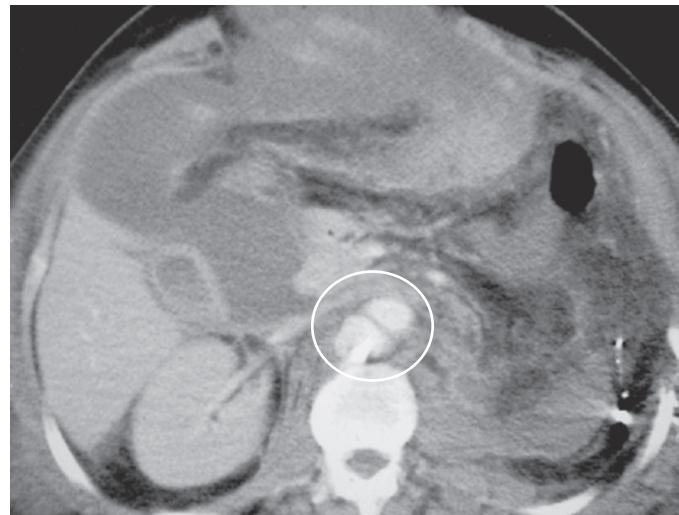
Postoperative computed tomography scan of a patient with a gunshot wound shows an abdominal aortic false aneurysm (circle).
